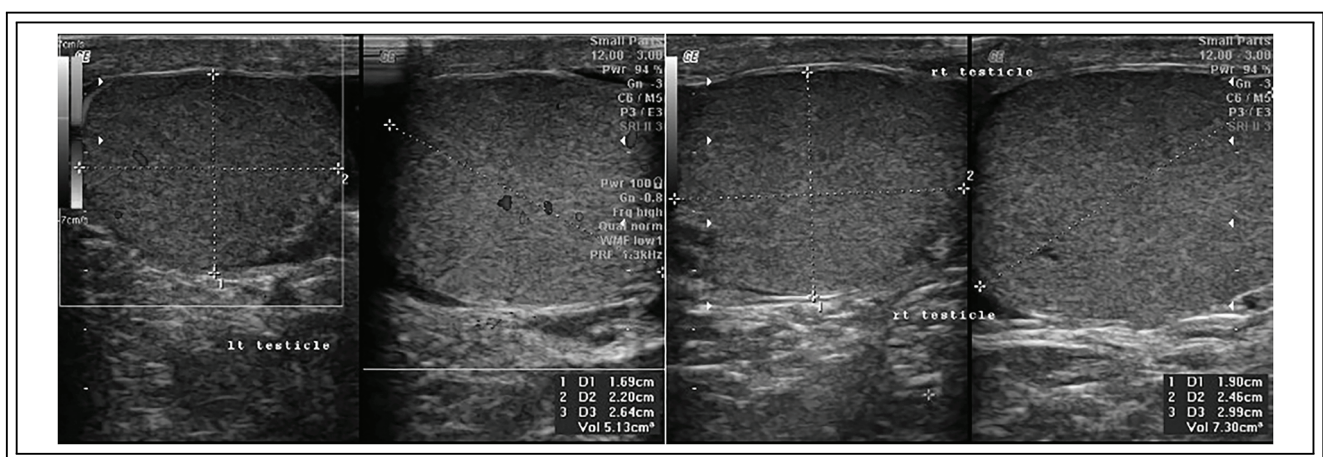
Doppler ultrasonography of the left and right testicles
